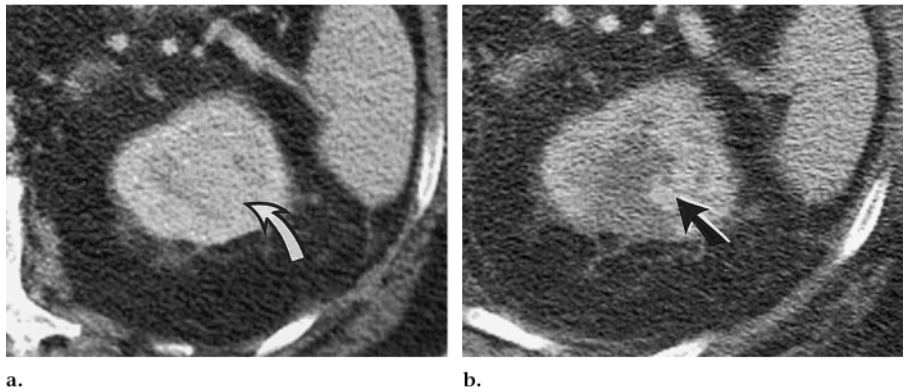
Patient 4. Large central tumor in a 59-year-old man in whom CT after initial RF ablation demonstrated incomplete treatment. (a) Transverse CT scan obtained before RF ablation shows a central enhancing renal cell carcinoma (arrow). (b) Transverse contrast-enhanced CT scan obtained after RF ablation shows a lateral crescent of residual enhancement (arrow) of the renal cell carcinoma. The residual enhancement is characteristic of residual renal cell carcinoma and was re-treated.
